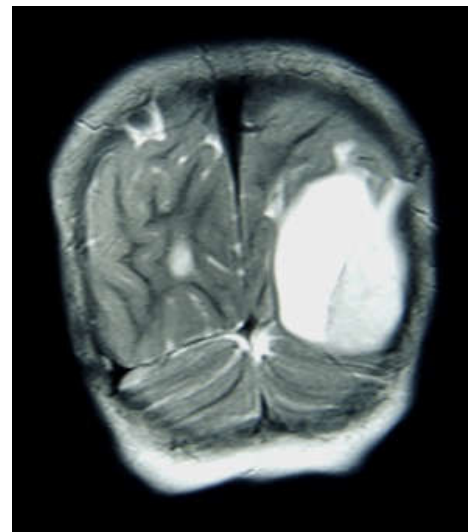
show MRI brain show solid and cystic lesion in the parieto-occipital lobe
